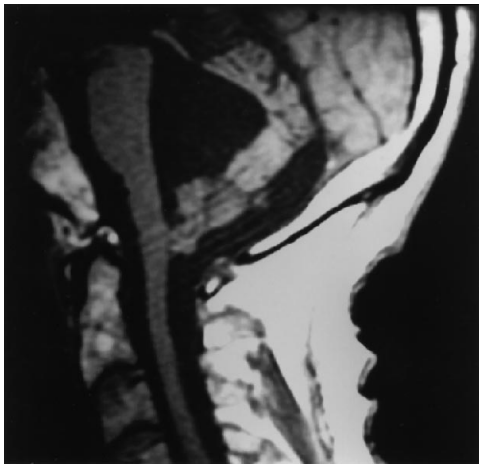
Sagittal T1-weighted MR image 41 days after removal of the paraspinous drain. This demonstrates ex vacuo dilatation of the fourth ventricle and return of the cerebellum to a normal position.
